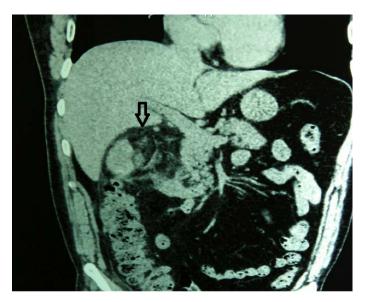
CT image of a case with previous caesarian delivery with stranding in the supra-umbilical and right hypochondriac region, which was most probably inflammatory in origin and suggestive of mesenteric panniculitis (arrow).
